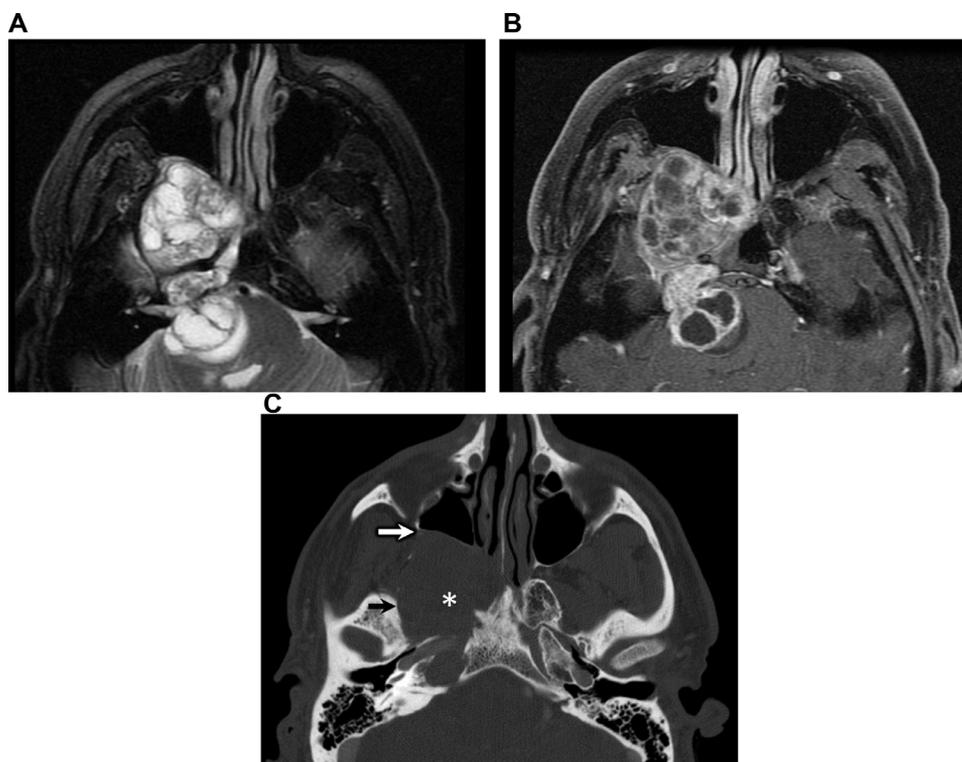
Surgically confirmed schwannoma of the right fifth nerve. (A) Axial T2-weighted fat-saturated and (B) axial T1-weighted postcontrast fat-saturated images demonstrate a large T2 hyperintense extra-axial heterogeneously enhancing fusiform mass with cystic change typical of a schwannoma extending from the right fifth nerve root entry zone along the course of V2 to the right pterygopalatine fossa. (C) Axial contrast-enhanced CT in bone window. There is associated benign-appearing pressure erosion and remodeling of the skull base (black arrow) and posterior wall of the right maxillary sinus (white arrow) due to long-standing slow growth of the schwannoma (white asterisk).
